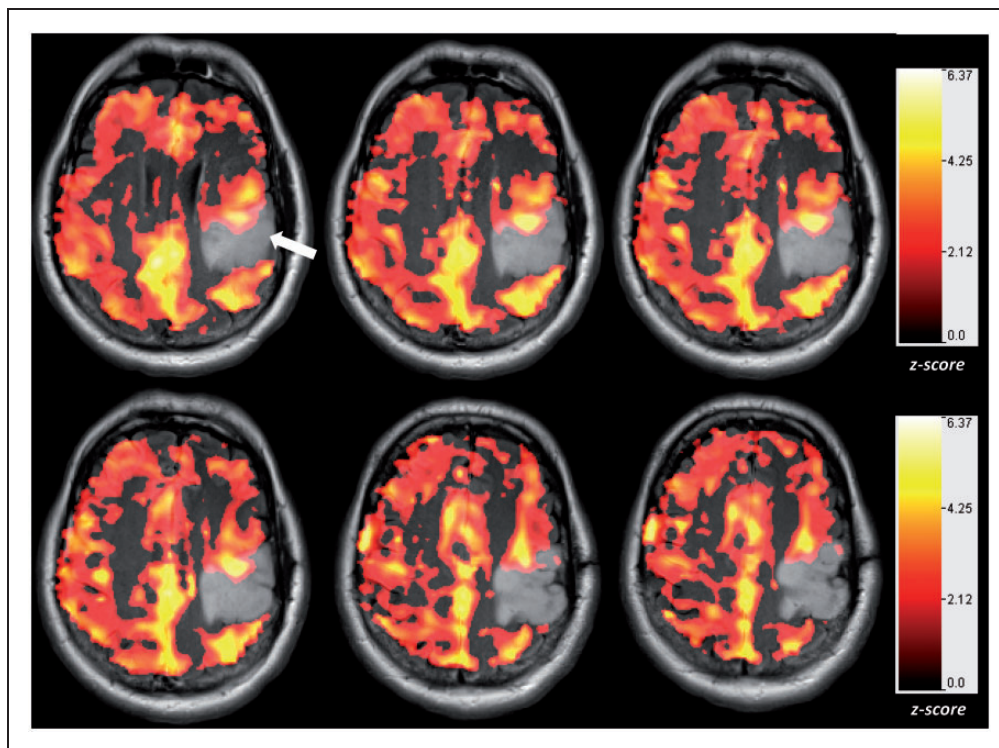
Neurovascular uncoupling in the tumor-affected brain hemisphere relative to the unaffected contralateral hemisphere: Cerebrovascular reactivity (CVR) maps overlaid on T2 FLAIR images obtained on a 7T MRI system during performance of a breath-hold task for a patient with a low-grade oligoastrocytoma (WHO grade II). The CVR maps were generated using a general linear model analysis in which the breath-hold hypercapnia state was contrasted with the baseline normal breathing blocks. Notice that within and in the immediate vicinity of the tumor, there is abnormally decreased and in some areas absent CVR (arrow) relative to the normal contralateral hemisphere. This is an indication of the presence of neurovascular uncoupling (NVU). All CVR maps were thresholded at a z-score > 1.0 .
